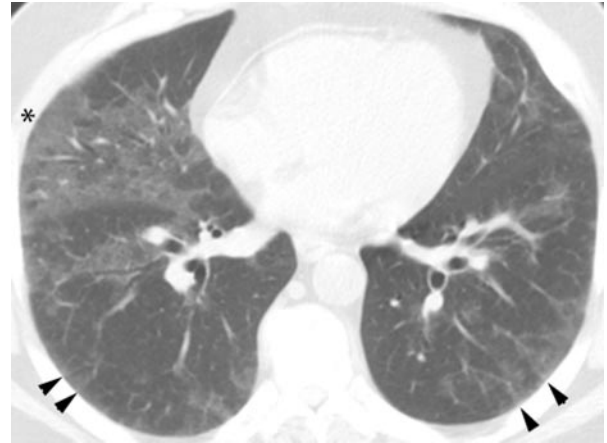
Chest computed tomogram. An image from the tomography pulmonary angiogram taken just inferior to the carina shows ground glass opacities, as well as prominent septal lines at the dependent pleural edge (arrowheads). The asterisk marks the site where the biopsy would be taken. No abnormalities are visible on the mediastinal window.
